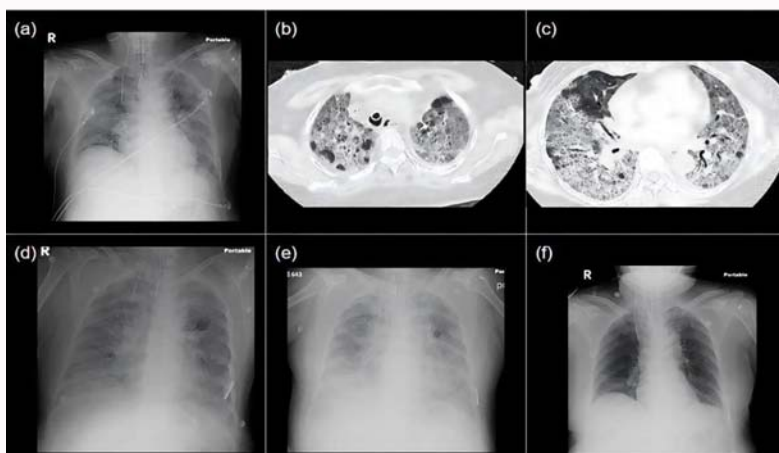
(a) First day of chest radiograph. (b) First day upper to middle region of chest CT. (c) First day middle to lower chest CT. (d) Second day of chest radiograph. (e) Fourth day of chest radiograph. (f) 10th day of chest radiograph.
